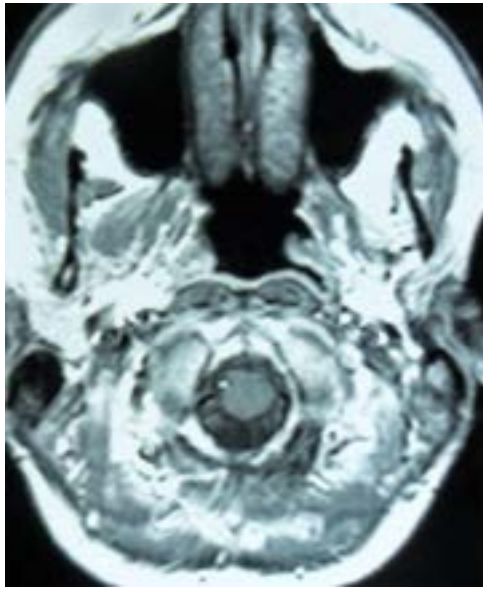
Postoperative axial T1 MRI with gadolinium contrast showing the area to be tumor free.
